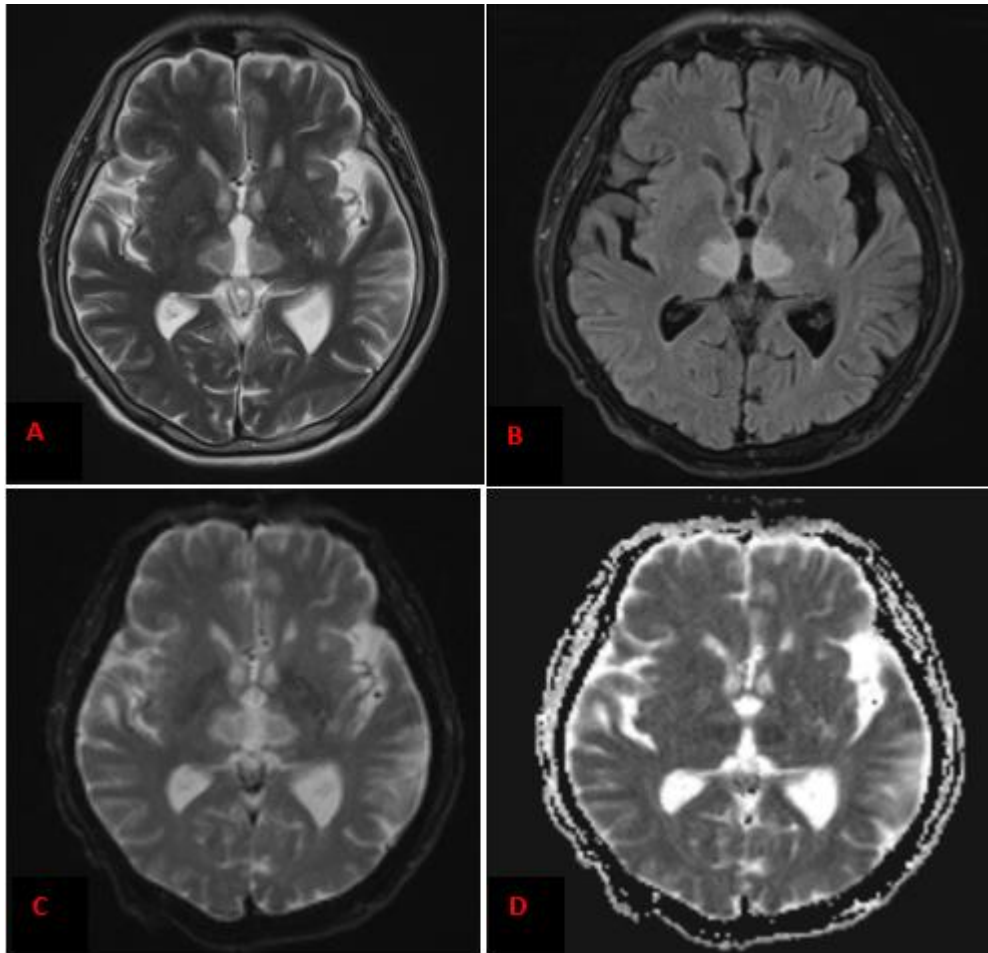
MRI Brain images. T2WI, axial FLAIR and DWI showing hyperintensities at bilateral thalami (A,B and C). ADC showing hypointensities at bilateral thalami.
